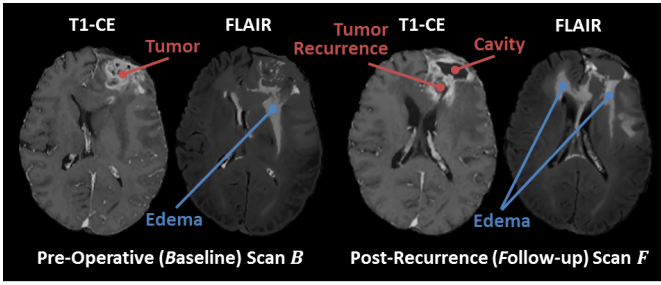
An example of the pre-operative scan B and the corresponding post-recurrence scan F . The pre-operative scan B clearly shows the tumor in the T1-CE scan and edema in FLAIR scan. Edema is also clearly visible in the FLAIR scan of the post-recurrence scan F . The T1-CE of F now shows resection cavity and tumor recurrence.
